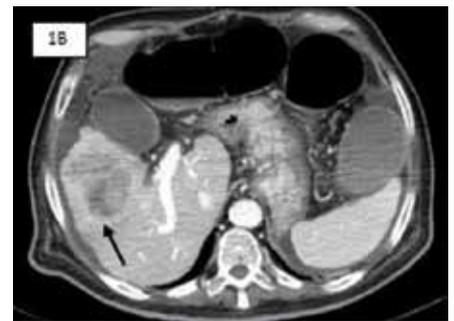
(a,b,c) - Positron Emission Tomography and Computed Tomography (PET-CT) images (axial and coronal) showing hypermetabolic avid mass in right lobe of liver (black arrow); (d,e): Corresponding axial and coronal CECT images showing heterogeneously enhancing mass lesion in right lobe liver with non-enhancing necrotic areas inferiorly (black arrow)
